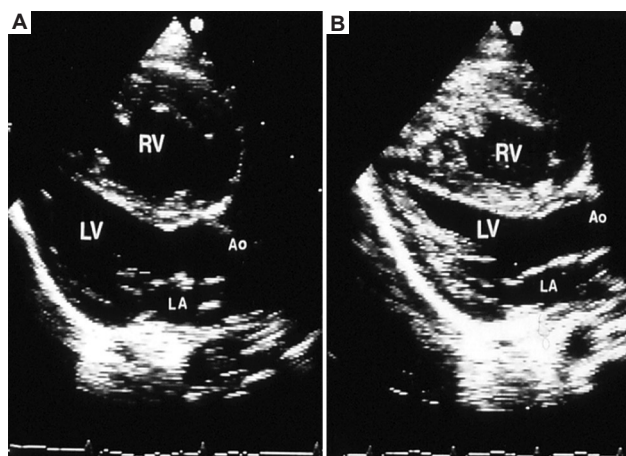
A two-dimensional echocardiogram performed before balloon pulmonary valve dilatation demonstrates (A) a dilated right ventricle (RV). Following successful balloon pulmonary valve dilatation, the RV size decreased (B).
